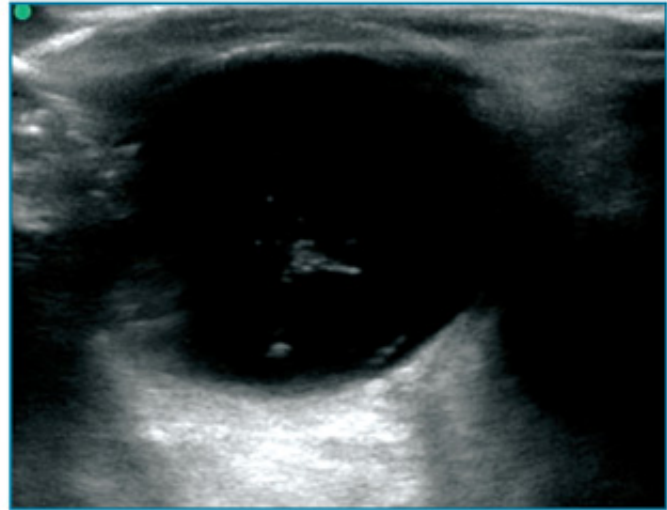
Ocular ultrasound showing a vitreous hemorrhage. In this image, the hemorrhage more clearly appears as a heterogeneous mass of free floating debris.
